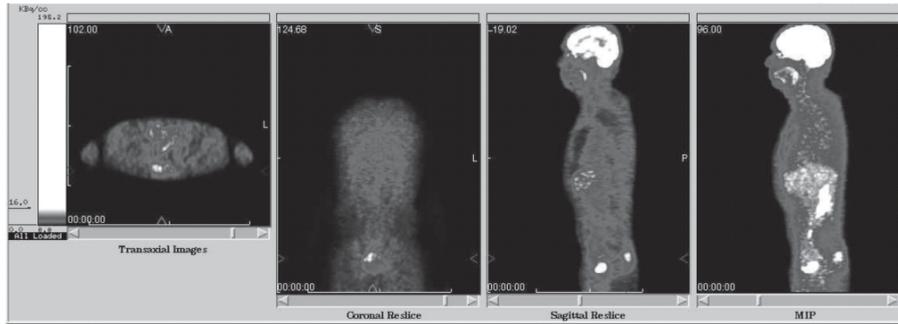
Whole body FDG-PET in a diagnosed patient of primitive neuroectodermal tumour of the right proximal femur at diagnosis. Note the widespread irregular FDG uptake in the skeleton, suggesting bone marrow involvement in addition to the avid FDG uptake in the primary. Bone scan shows disease only when there is cortical involvement and is negative when there is only marrow involvement. Reprinted with permission from Leadership Medica for Alavi et al.
